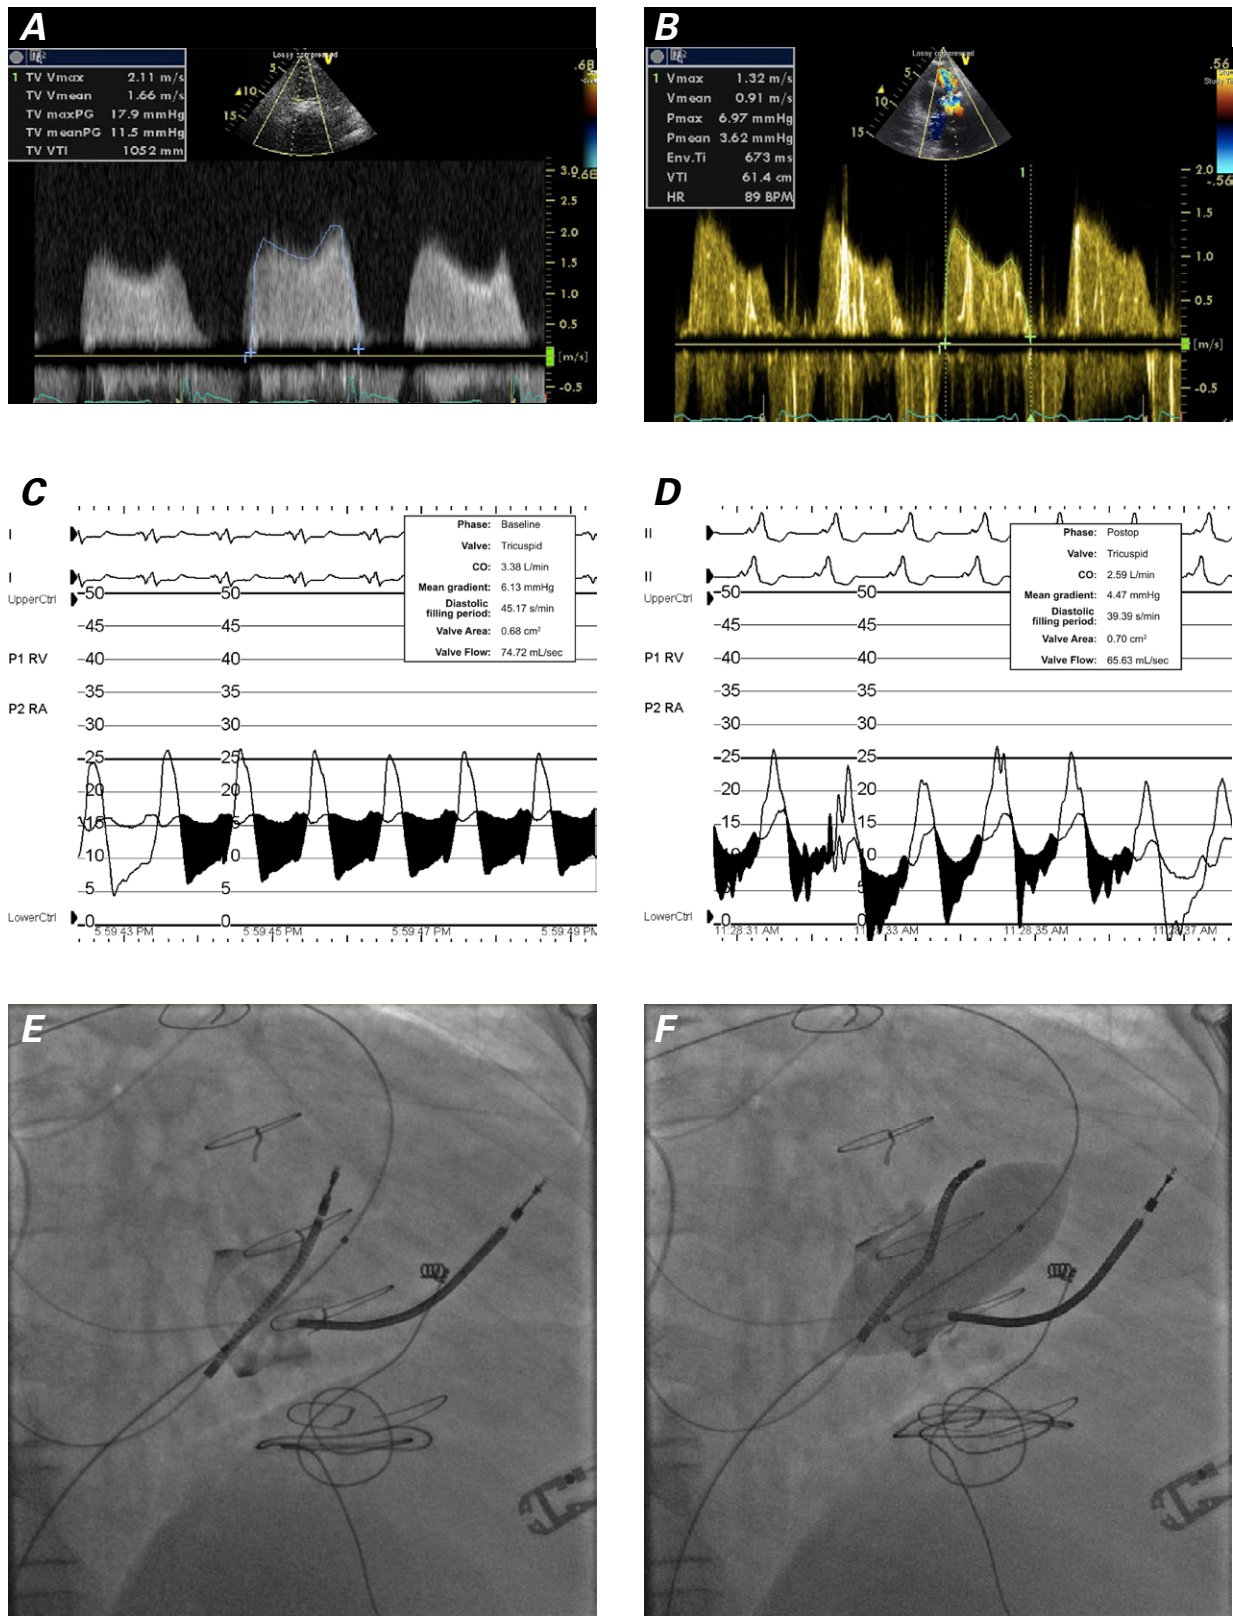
Patient 2. Transthoracic echocardiograms show peak and mean transvalvular gradients across the tricuspid valve of A) 18 and 12 mmHg before valvuloplasty and B) 7 and 4 mmHg after valvuloplasty, respectively. Tracings from a Swan-Ganz balloon-tipped catheter, which was floated through the bioprosthetic tricuspid valve to measure right atrial and right ventricular pressures simultaneously, showed mean tricuspid valve gradients of C) 6 mmHg before valvuloplasty and of D) 4 mmHg after valvuloplasty. Fluoroscopic images show E) wire placement and F) the Tyshak-X balloon fully inflated across the tricuspid valve.
